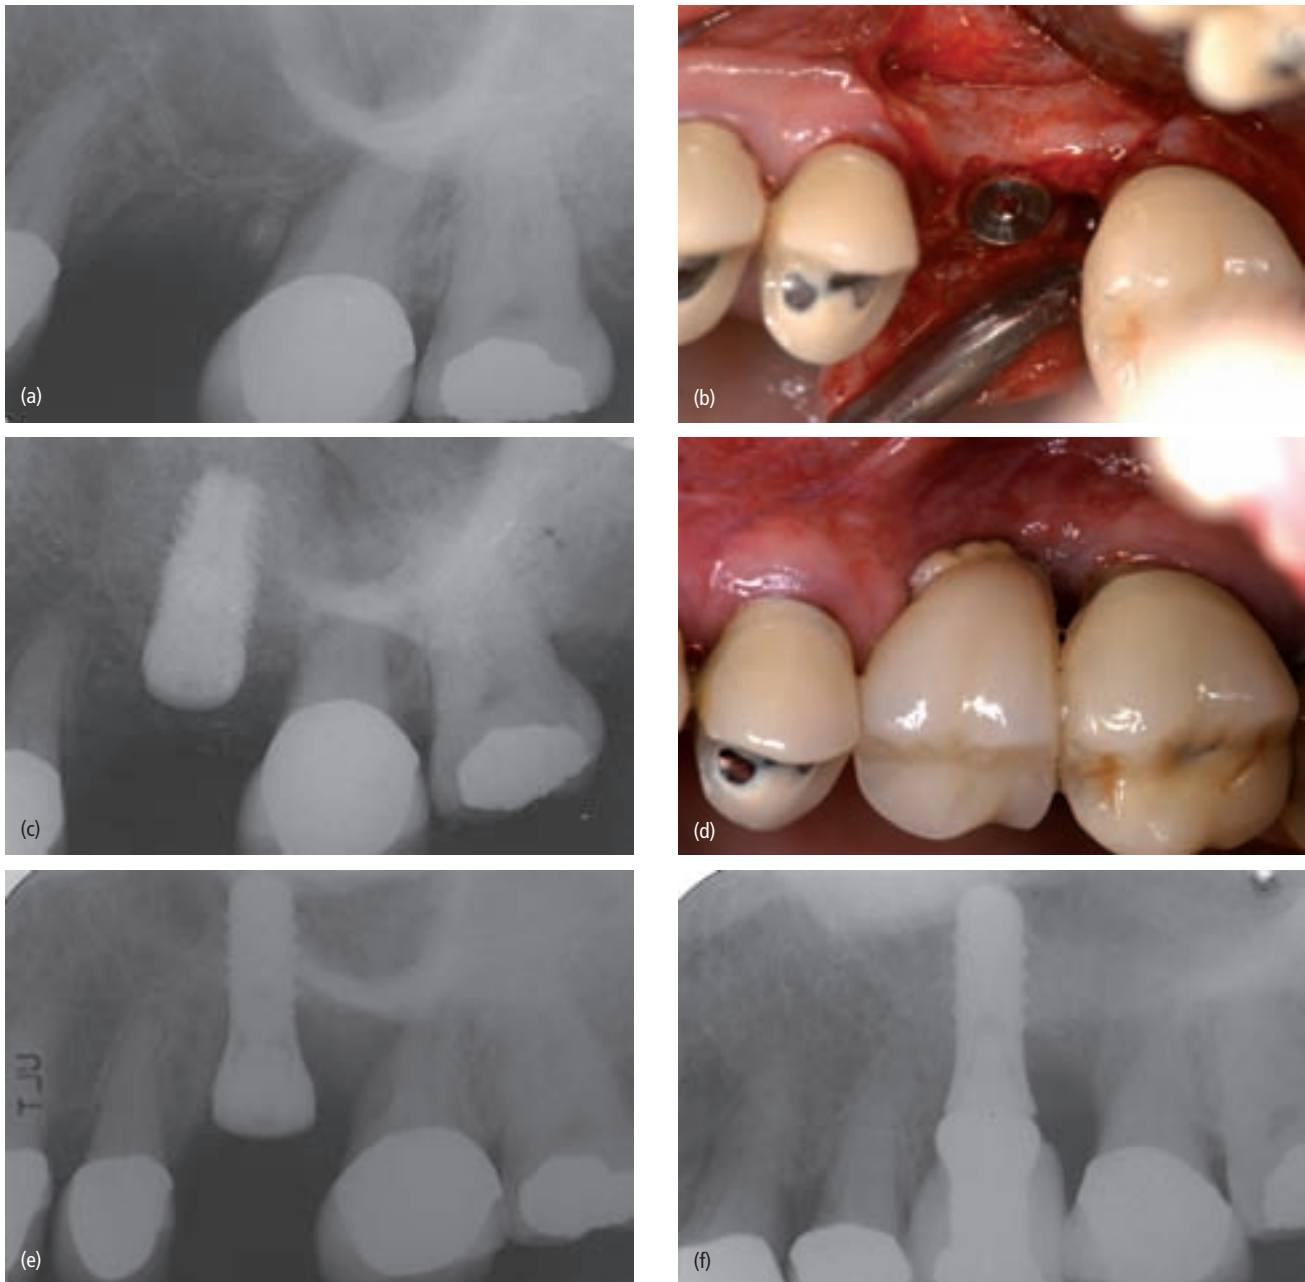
(a) Presurgical radiograph of the sinus area before treatment. Presurgical measurement is less than 5 mm of native bone. The residual root tip located mesial to the second molar was removed at the time of implant placement. (b) Clinical view of the implant placement at the site of the maxillary left first molar simultaneous to osteotome sinus floor elevation. The implant was submerged and allowed to heal for 6 months. (c) Radiograph showing a 10 mm implant placed in conjunction with the use of mineralized freeze-dried bone augmentation of the sinus area. The graft material appears to be contained. (d) Clinical view of the crown installed on the implant. The implant failed within weeks of its restoration. (e) Radiographic taken after placing the second implant at this failed site. The implant was placed with the abutment exposed. (f) Radiographic view of the second implant restored and in function for 3 years.
